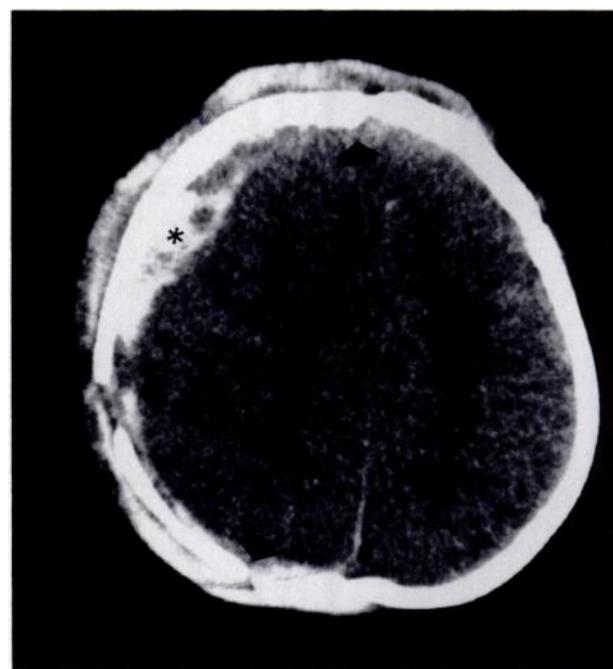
Computed tomographic scan of an 11-month-old child who was an unrestrained passenger in a motor vehicle accident. Despite extensive fractures (arrows) and focal contusions and extraaxial hemorrhage (asterisk), the child made a good recovery.
